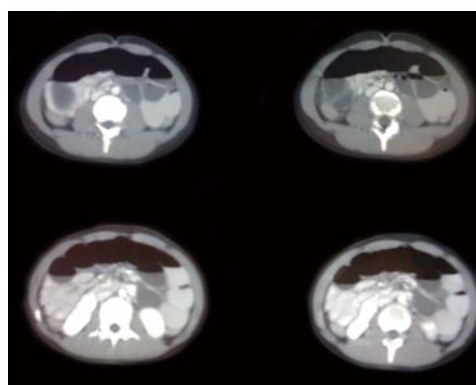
Computed tomography revealed distention of the small intestine at the level of jejunum and ileus. A mass lesion was identified with concentric rings of fat and soft- tissue attenuation.
